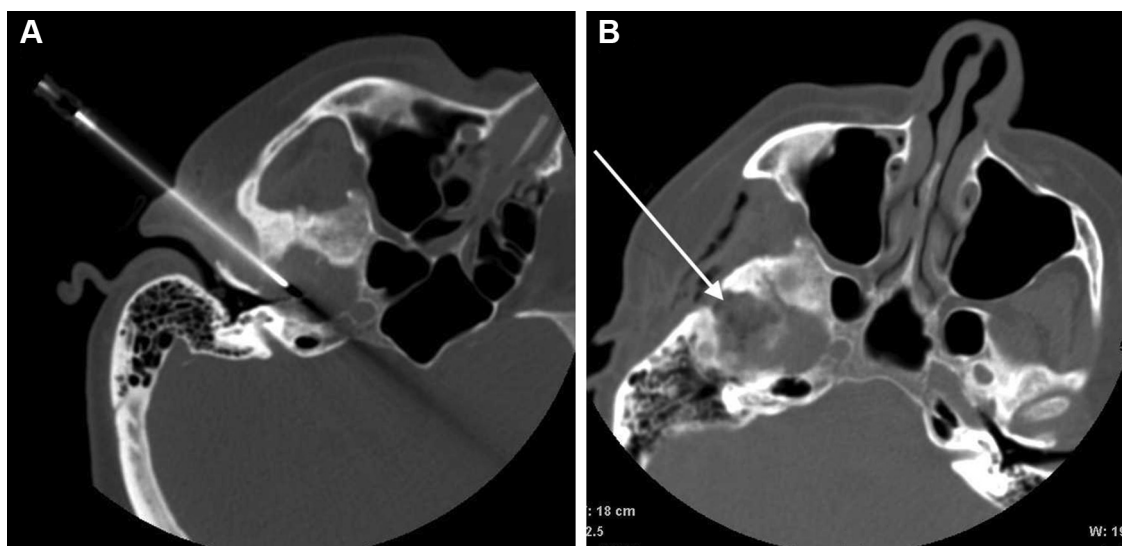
Percutaneous computed tomography (CT)-guided needle biopsy and doxycycline foam sclerotherapy. Biopsy performed with 14G guiding needle placed through the roof of the tempomandibular joint (A). Injected doxycycline foam has air
